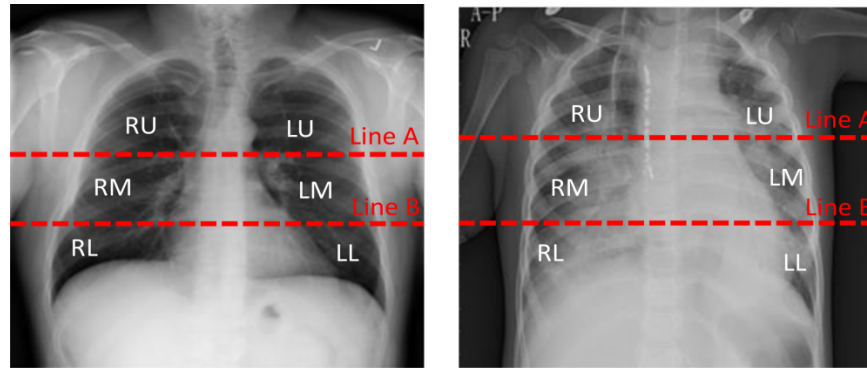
X-ray of healthy individual (left), and a patient with pneumonia (right).
